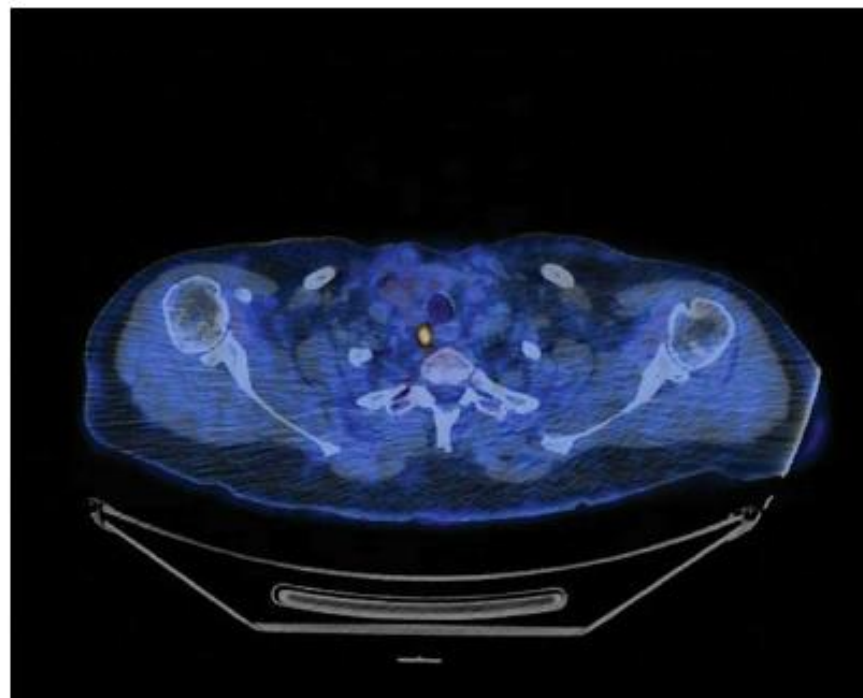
PET/CT axial fusion projection performed under TSH suppression — accumulation of the [^{18}F]FDG in the right mediastinal lymph node
